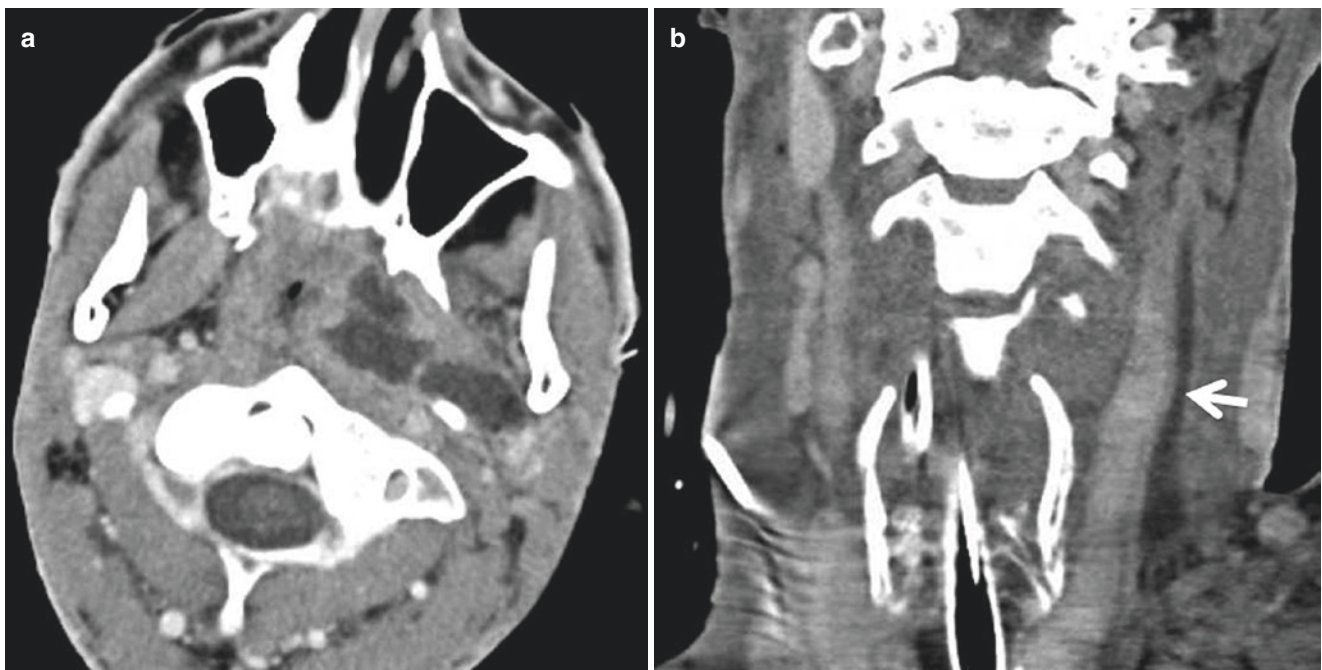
Lemierre syndrome. HIV+ patient with throat pain and fever. (a) Axial contrast-enhanced neck CT demonstrates left tonsillar and parapharyngeal abscess. (b) Coronal image reveals thrombosis of left internal jugular vein (arrow). (c) Axial image through the lung apices
